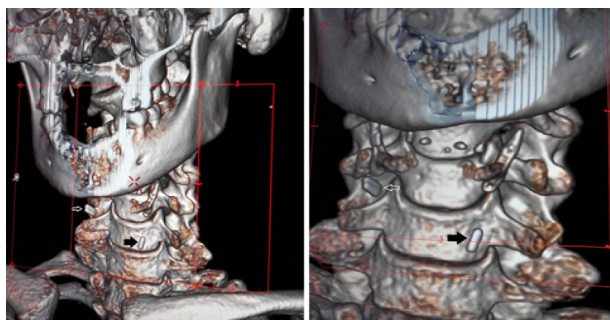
Multi slice CT with volume reduction showing 2 oval shaped foreign bodies in relation to the soft tissue of the anterior neck on both sides at the level of C6 on the right side and C7 on the left side, size 5-6 mm in length with density of 2800HU. Consistent with surgical clip in view of previous thyroidectomy.
